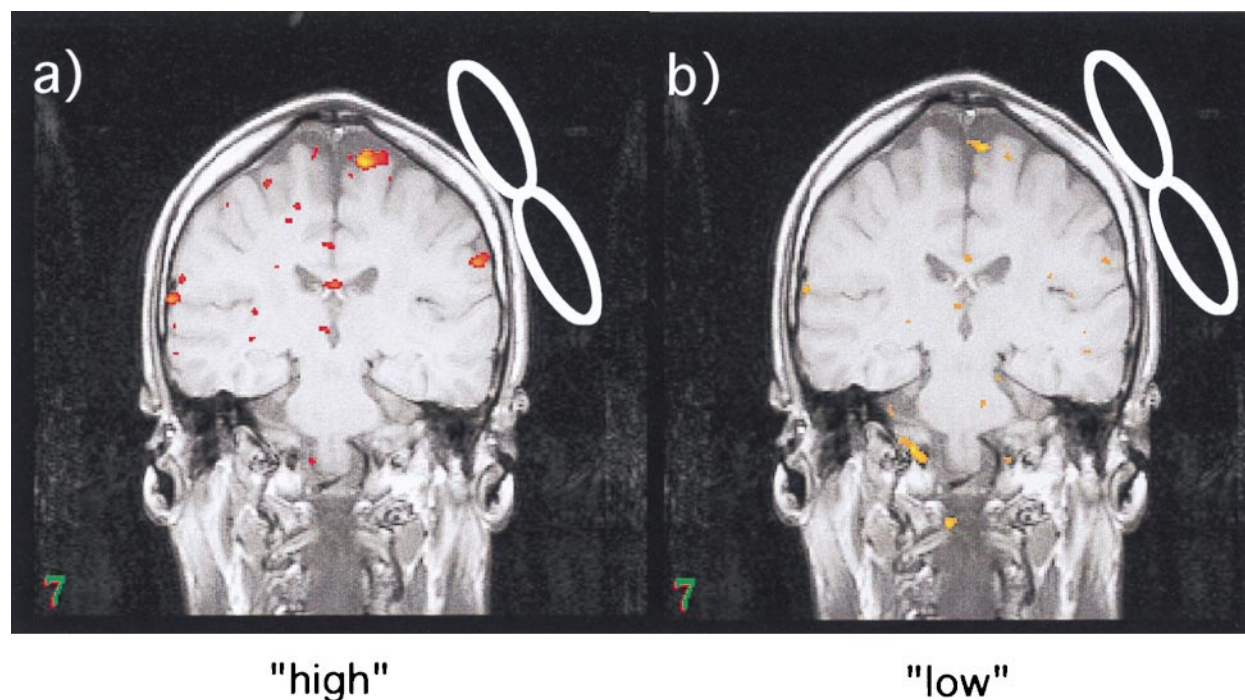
Coronal MRI images of one subject directly below the TMS coil. (A) 110% MT (high) and (B) 80% MT (low). Areas of significant ($p < .001$) activation are superimposed in color, activity increasing from yellow to orange to red, and the position of the coil has been indicated. Note the increased number of significant pixels in this subject during the high intensity stimulation task (HMR), and the relative absence of activity directly under the coil.
